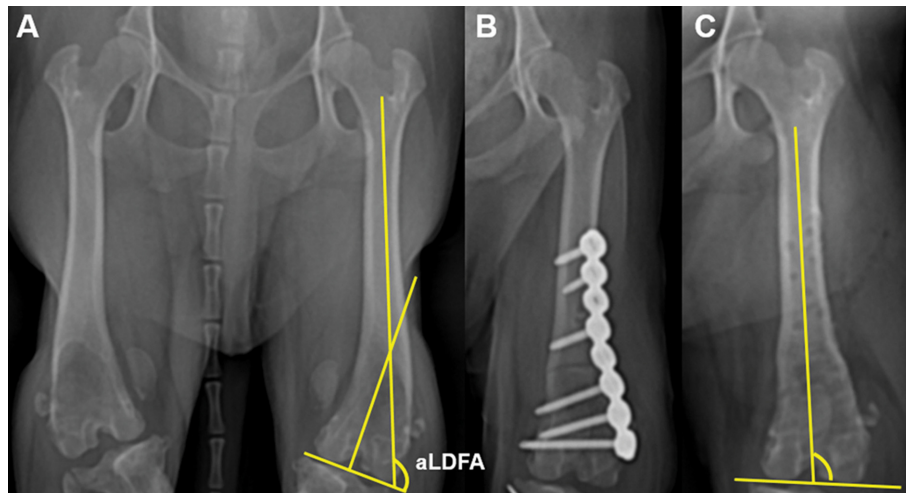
Pre- and postoperative craniocaudal femoral projection from case 4 showing reference lines for the radiographic measurement of the distal femoral varus deformity (A and B). Case 4 performed 2 staged bilateral DFO, and the plate on the left limb was removed 8 months later (C). Note the improved limb alignment and patellar location with aLDFA 96.3° postoperatively compared to the preoperative radiograph with aLDFA 110° (C). aLDFA, anatomic lateral distal femoral angle; DFO, distal femoral osteotomy.
